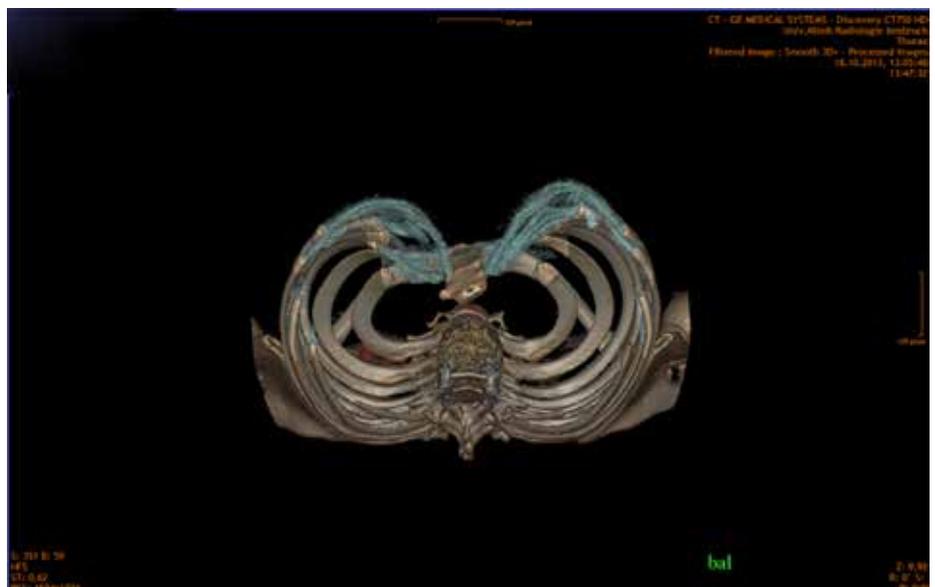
Preoperative 3D VR-CT scan of a 13-year old male with an asymmetrical funnel chest.
